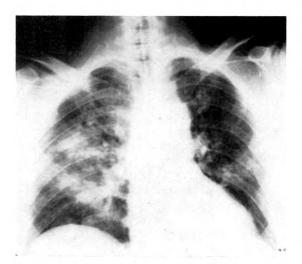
Case II. Admitting chest roentgenogram shows patchy density in the right lung on the side of the blunt trauma.
